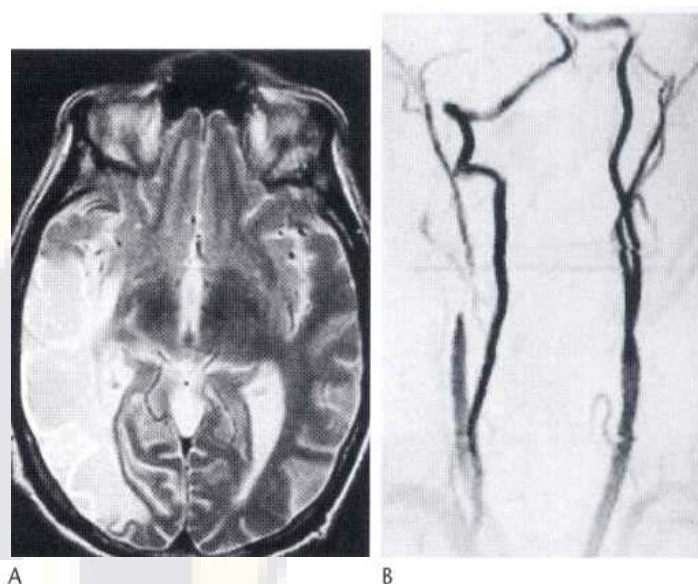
(A) MRI shows large area of right hemisphere with high signal. (B) MRA shows occlusion of right internal carotid artery.
